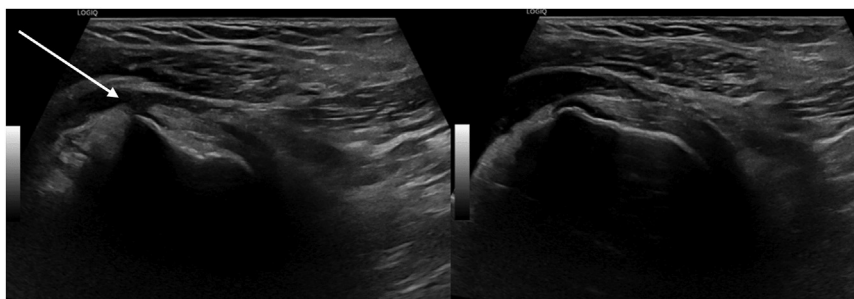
Transverse ultrasonography of the right shoulder demonstrating a full thickness tear of the supraspinatus/infraspinatus tendon with communication of fluid from the glenohumeral joint to the subacromial space (white arrows).
